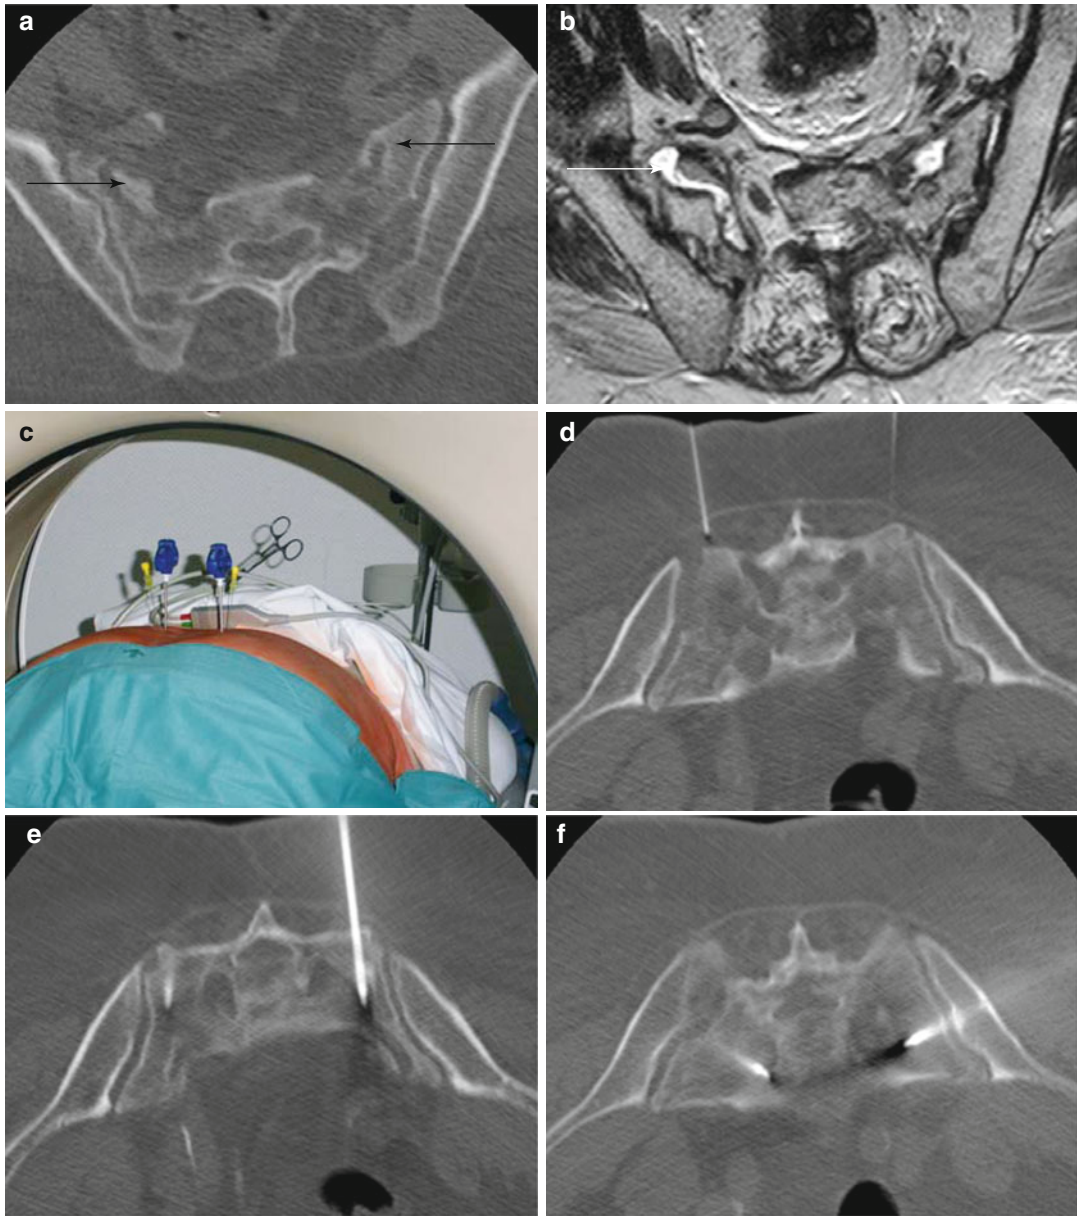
(a–f) Sacroplasty: pretreatment axial CT (a) and MR images demonstrate the fractures in both sacral alae (*black arrows*). The fractures are parallel to the sacroiliac joints and show edema on T2-weighted MRI images (*white arrows*) (b). CT setup is used for needle placement (c, d). Bilateral sacroplasty is performed using a two-sided
